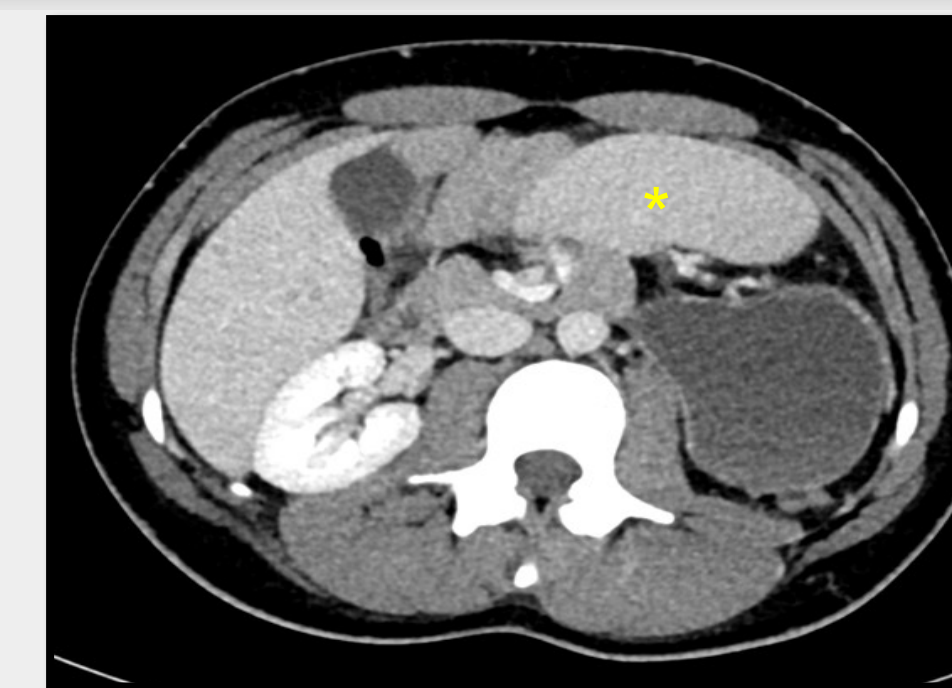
Axial CT image showing twisted mesenteric vessels at the mesenteric root, with the spleen lying more anteromedially than expected (*).
